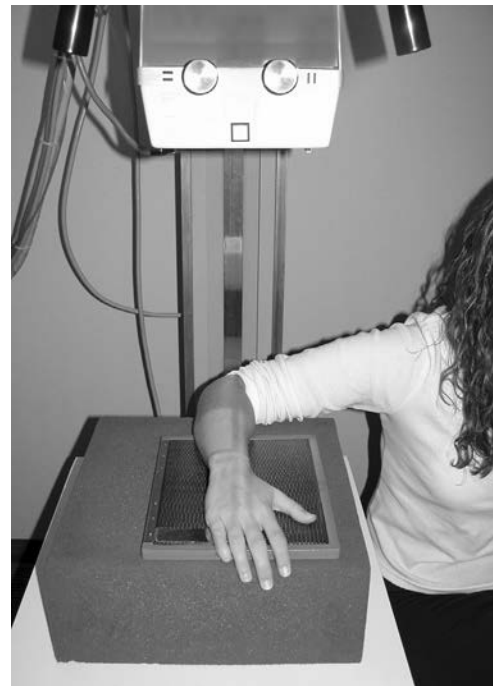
Technique for neutral rotation radiograph with wrist neutral, forearm pronated, elbow flexed 90 degrees, and shoulder abducted 90 degrees.
